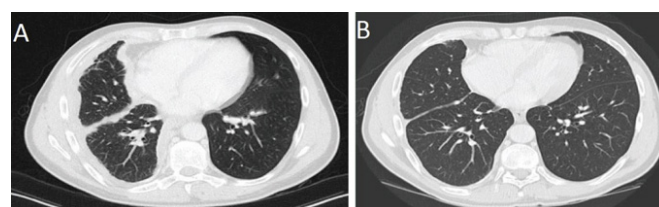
CT scan taken from a patient with a right-sided mesothelioma before (A) and after treatment (B) with TargomiR, an Engineic Delivery Vehicle targeted against EGFR-specific antibody and located with miR-16-based mimic microRNA.⁵⁴
